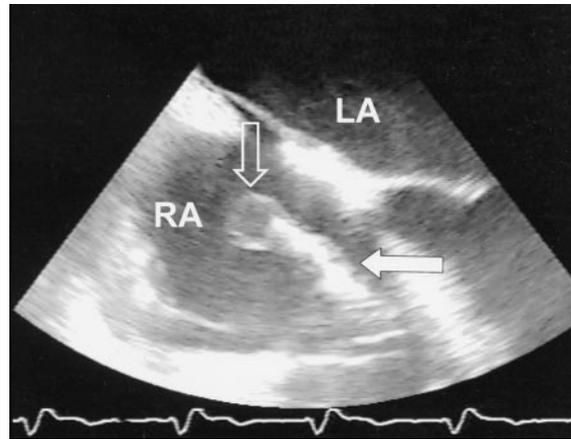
Transesophageal echocardiographic view of the left atrium (LA) and right atrium (RA). A pacemaker lead (filled arrow) is seen as it crosses the tricuspid valve. The lead is thickened by infective material, and there is a round mobile vegetation (open arrow) attached to its right atrial portion.
